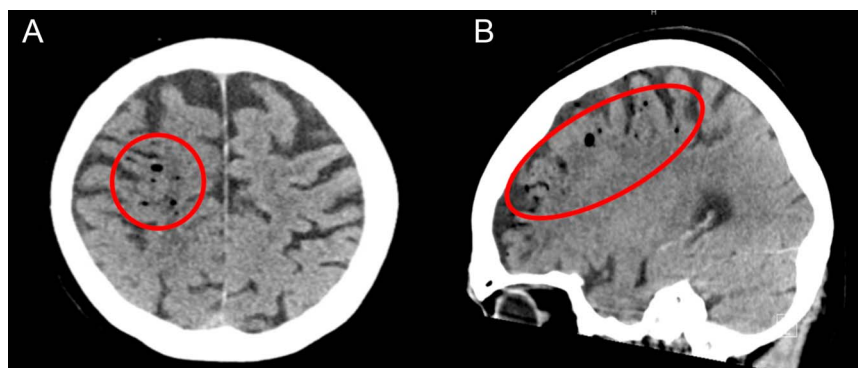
(A) Axial and (B) sagittal views of cranial computed tomography showing diffuse foci of air (red circles) in the right parietal lobe.
